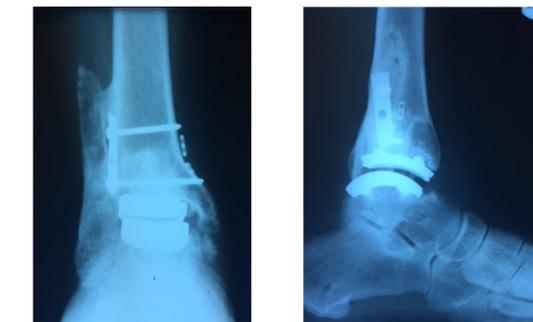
AP and LAT x-rays demonstrating rectus alignment of the ankle joint at 5 years status post total ankle replacement
